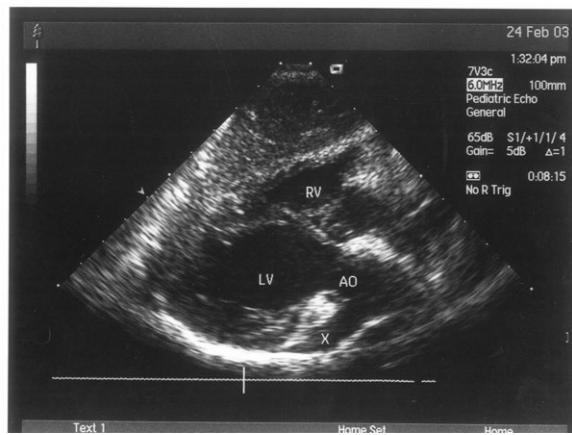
In the modified parasternal long axis view, a large vascular structure originates from the left coronary cusp. AO indicates aorta; LV, left ventricle; RV, right ventricle; X, vascular structure.
